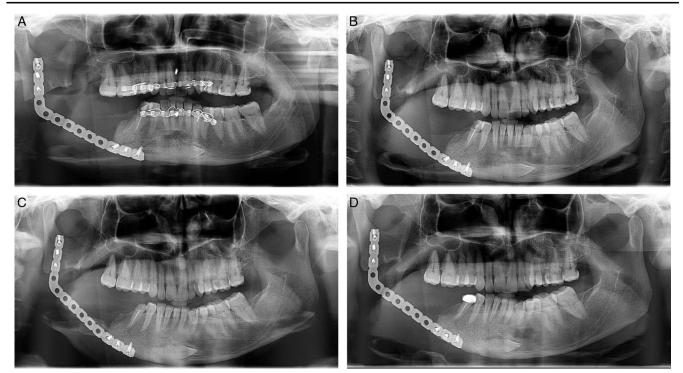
(A) One week postoperative panoramic radiograph of the mandible reconstructed. (B) Four months postoperative panoramic radiograph. (C) Seven months postoperative panoramic radiograph. (D) Fourteen months postoperative panoramic radiograph.
